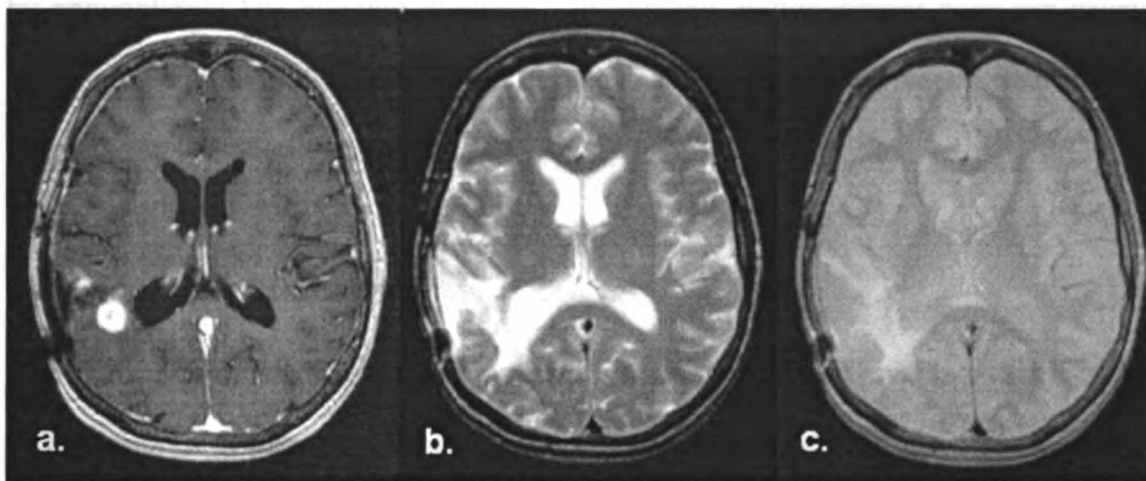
a) T1-weighted image post-gadolinium, b) T2-weighted image, and c) PD-weighted images of a high-grade glioma
